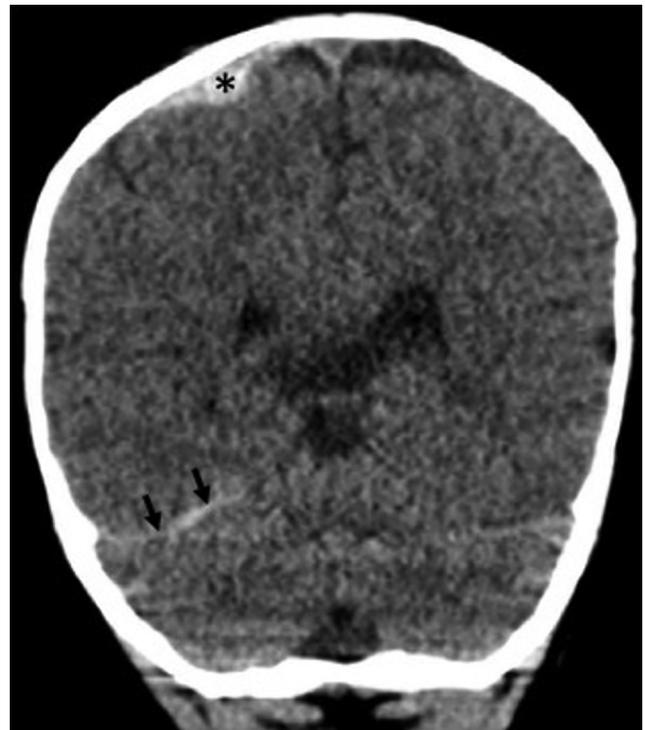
26-month-old boy with severe hemophilia A. Unenhanced head CT in the coronal plane shows extra-axial hematoma (asterisk) and a subdural hematoma of the tentorium (arrows). This child presented with partial febrile seizures (38.5 °C) and a normal neurological examination between seizure episodes. Head trauma two days earlier was reported.
